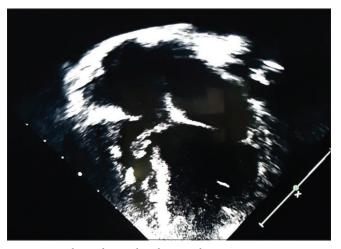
Echocardiography showing large vegetation 16*7 mm attached to tricuspid leaflet.
